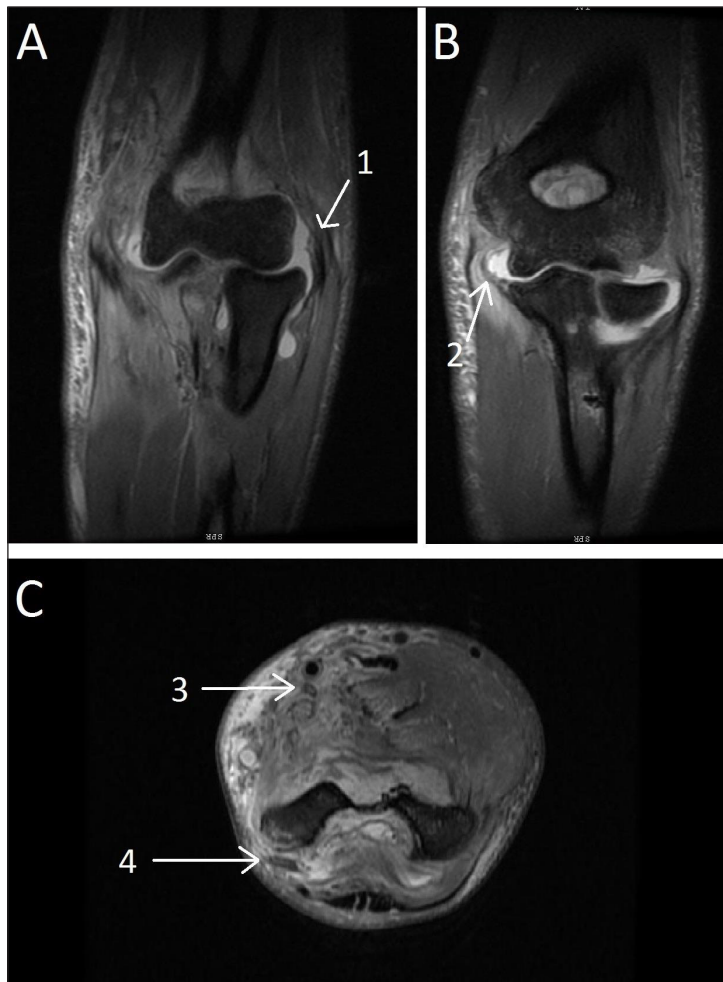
A–C – MRI scans of the right elbow joint three weeks after trauma. 1 – rupture of the lateral collateral ligament, 2 – rupture of the medial collateral ligament, 3 – median nerve oedema, 4 – ulnar nerve oedema
